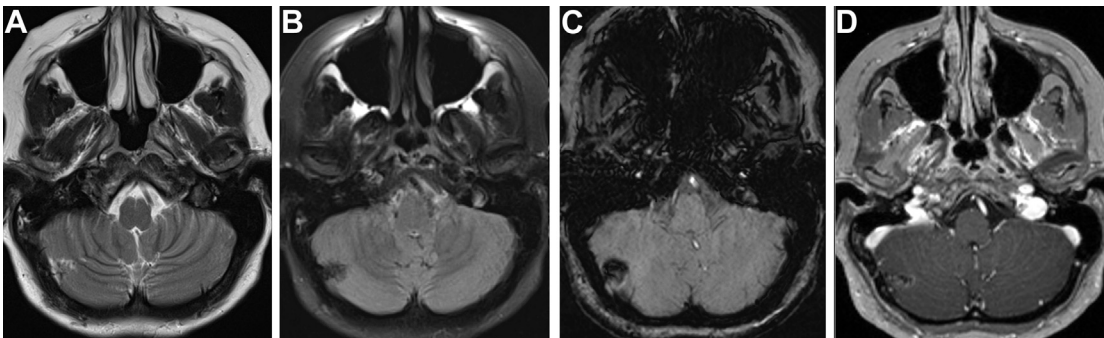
A 46-year-old woman with TSC2 mutation mosaicism. (A) Axial T2WI, (B) FLAIR, (C) susceptibility-weighted imaging, and (D) postcontrast T1WI showing a typical right cerebellar tuber, a wedge-shaped lesion in right cerebellum with susceptibility low signal caused by calcification and heterogeneous postcontrast enhancement.
